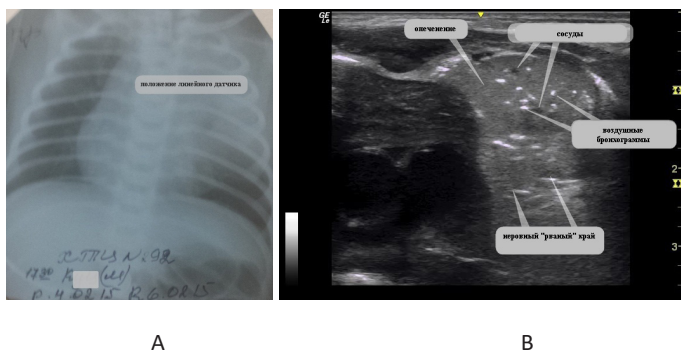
Newborn, 2nd day of life. A. The X-ray shows a homogeneous darkening of the upper lobe of the left lung. B. An ultrasound (the position of the transducer is indicated on the x-ray) is visualized
